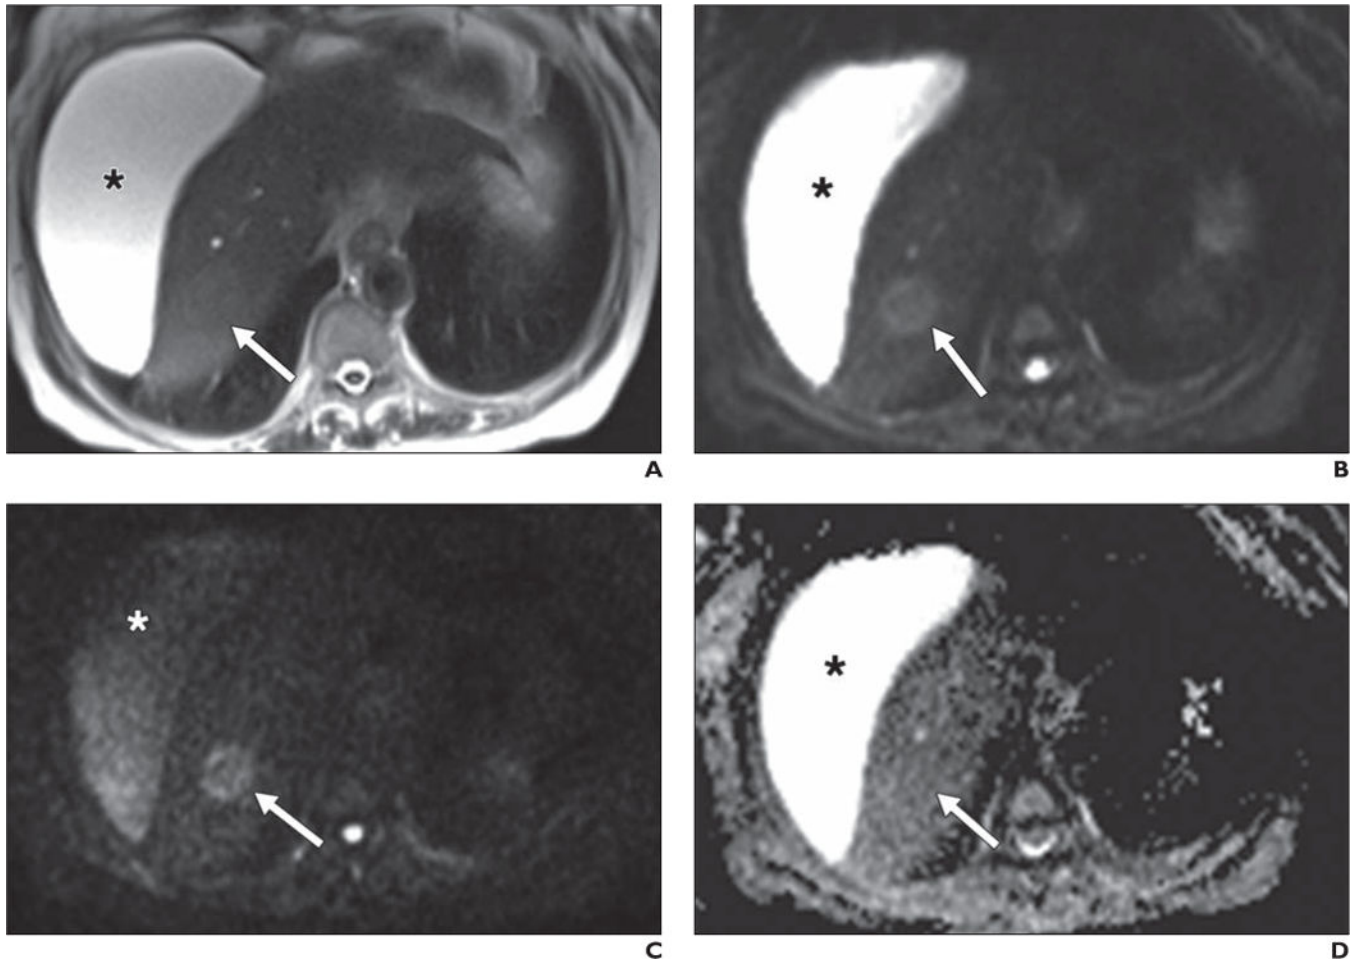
63-year-old woman with cirrhosis and new mass identified on ultrasound (not shown). A–D, Lesion (*arrow*) nearly isointense to background liver on axial T2-weighted single-shot fast spin-echo image (A) is well shown on low-b-value diffusion-weighted ($b = 50$) image (B). Retained signal on high-b-value ($b800$) image (C) suggests solid lesion, which as new finding in setting of cirrhosis is worrisome for hepatocellular carcinoma. Note abdominal ascites (*asterisk*), which decreases in signal intensity on high-b-value images, suggestive of simple fluid. This fluid was bright on ADC map (D). Dynamic imaging was not performed due to contraindication to gadolinium. This example also shows potential inconspicuity of solid lesion on ADC map (D) on background of cirrhotic liver.
